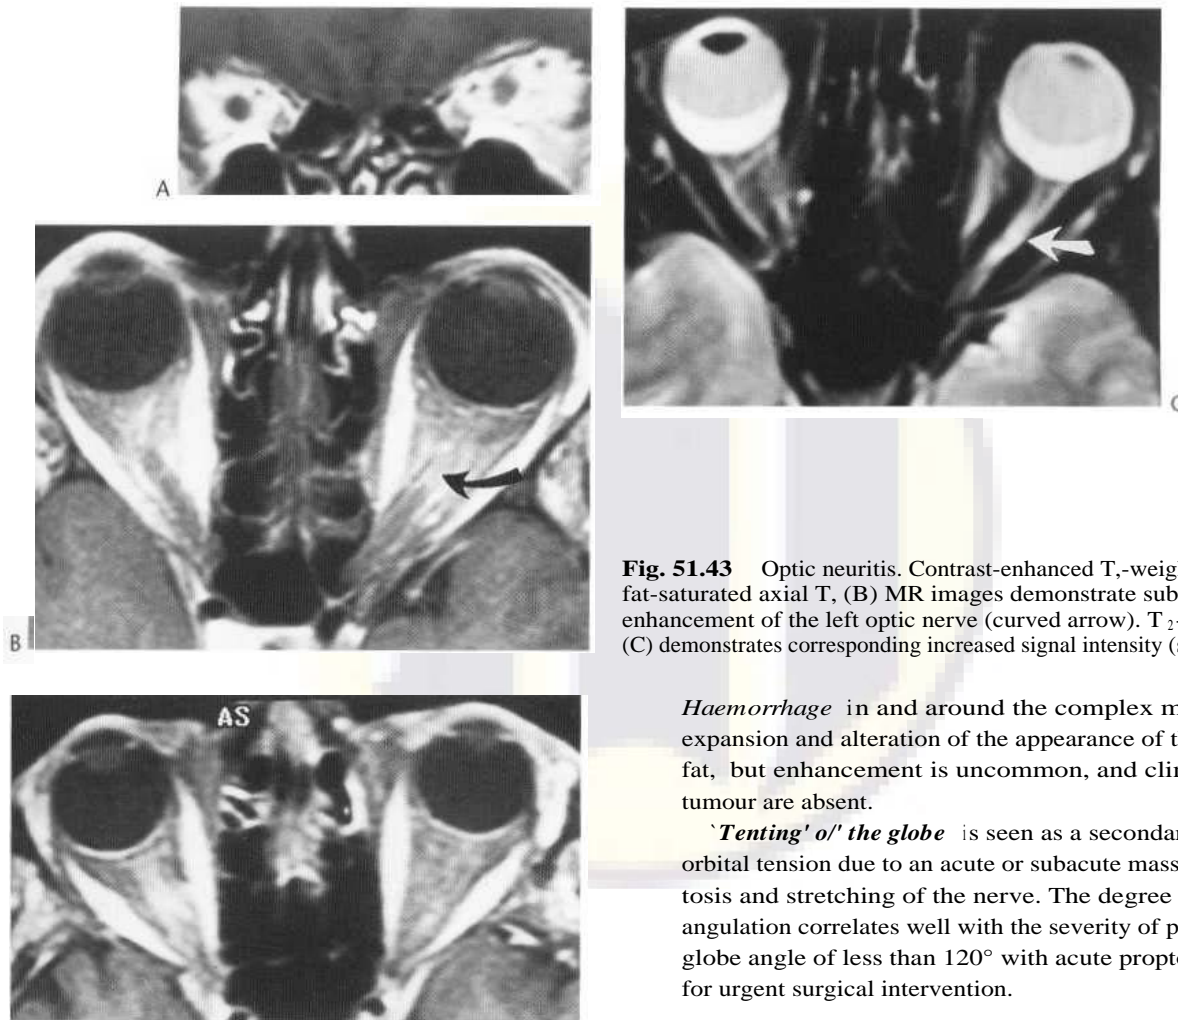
Optic neuritis. Contrast-enhanced T₁-weighted coronal (A) and fat-saturated axial T₁ (B) MR images demonstrate subtle enlargement and enhancement of the left optic nerve (curved arrow). T₂-weighted axial image (C) demonstrates corresponding increased signal intensity (straight arrow).
